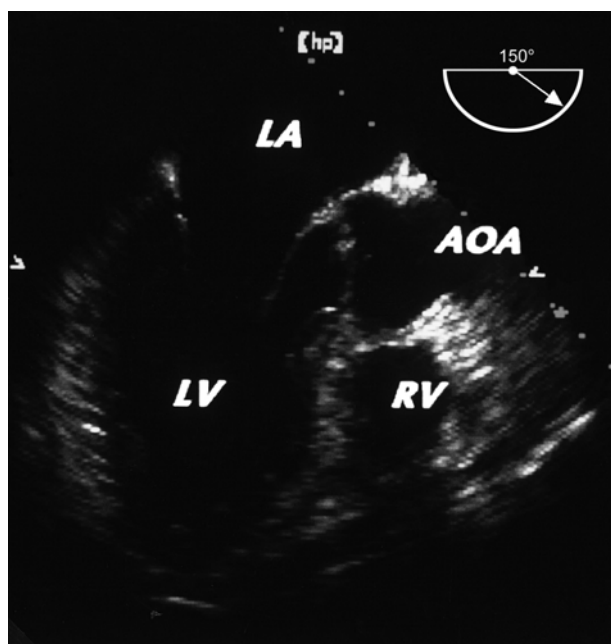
Transoesophageal long-axis view of the left ventricle.
